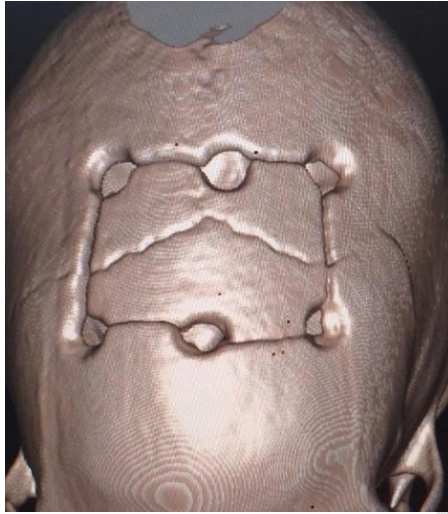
3D reconstruction of the follow up CT showing the configuration of the craniotomy and the burr holes.
